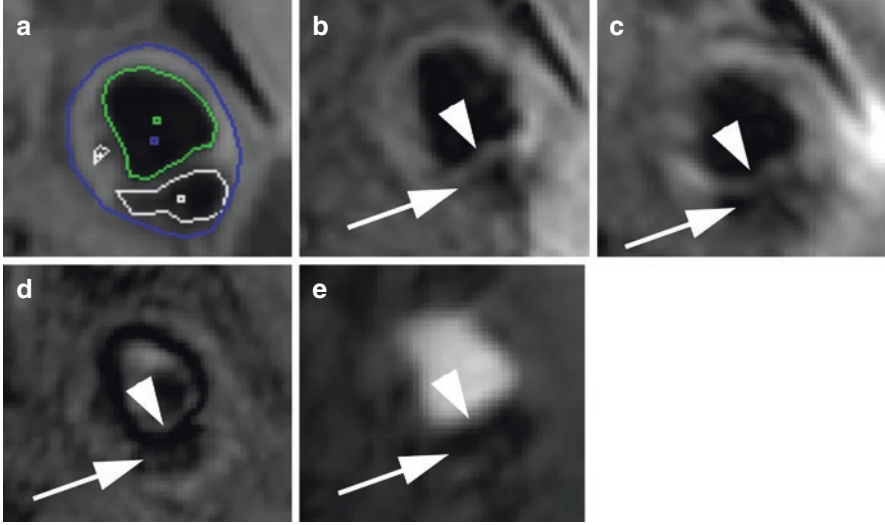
Carotid plaque vessel wall imaging with lipid rich necrotic core and fibrous cap. Segmented left carotid bifurcation plaque on 2D T1-weighted imaging (a) with lumen (green tracing), outer wall (blue tracing), and lipid rich necrotic core (LRNC, white tracing). 3D T1-weighted images (b) show low signal within the LRNC (arrow) and a thinned fibrous cap (arrowhead). Similarly, 3D T2-weighted images (c) show low signal within the LRNC (arrow) and a thinned fibrous cap (arrowhead). 3D MPRAGE (d) also shows low signal within the LRNC (arrow) and a difficult to see fibrous cap (arrowhead). On bright blood time-of-flight images (e), the LRNC (arrow) and fibrous cap (arrowhead) are not easily seen
